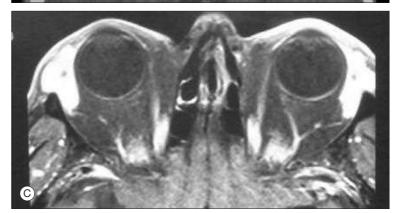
(A) A middle-aged man with several months of bilateral lacrimal gland enlargement due to sarcoidosis. On imaging, there is bilateral symmetrical enlargement of the lacrimal glands on both an axial CT scan (B) and an axial T1-weighted gadolinium-enhanced MRI (C).
